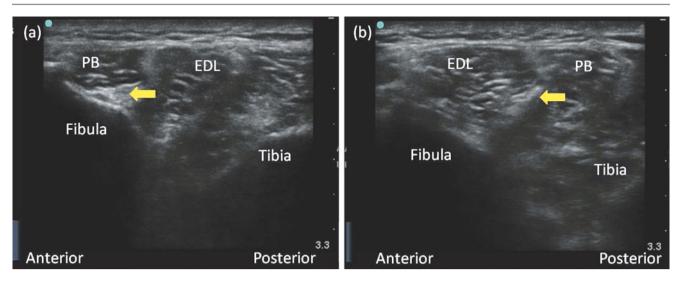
(a, b), Ultrasound images of the superficial peroneal nerve lying between the peroneus brevis muscle laterally and the extensor digitorum longus muscle medially. EDL extensor digitorum longus, PB peroneus brevis
